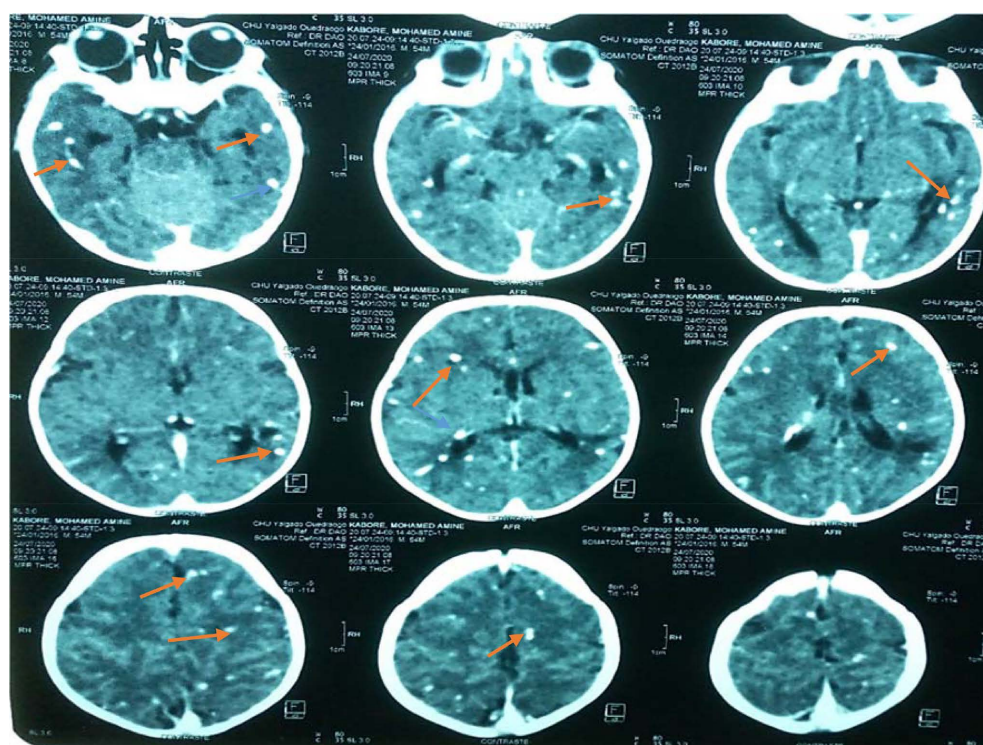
BS cerebral computed tomography displaying multiple disseminated calcifications.
